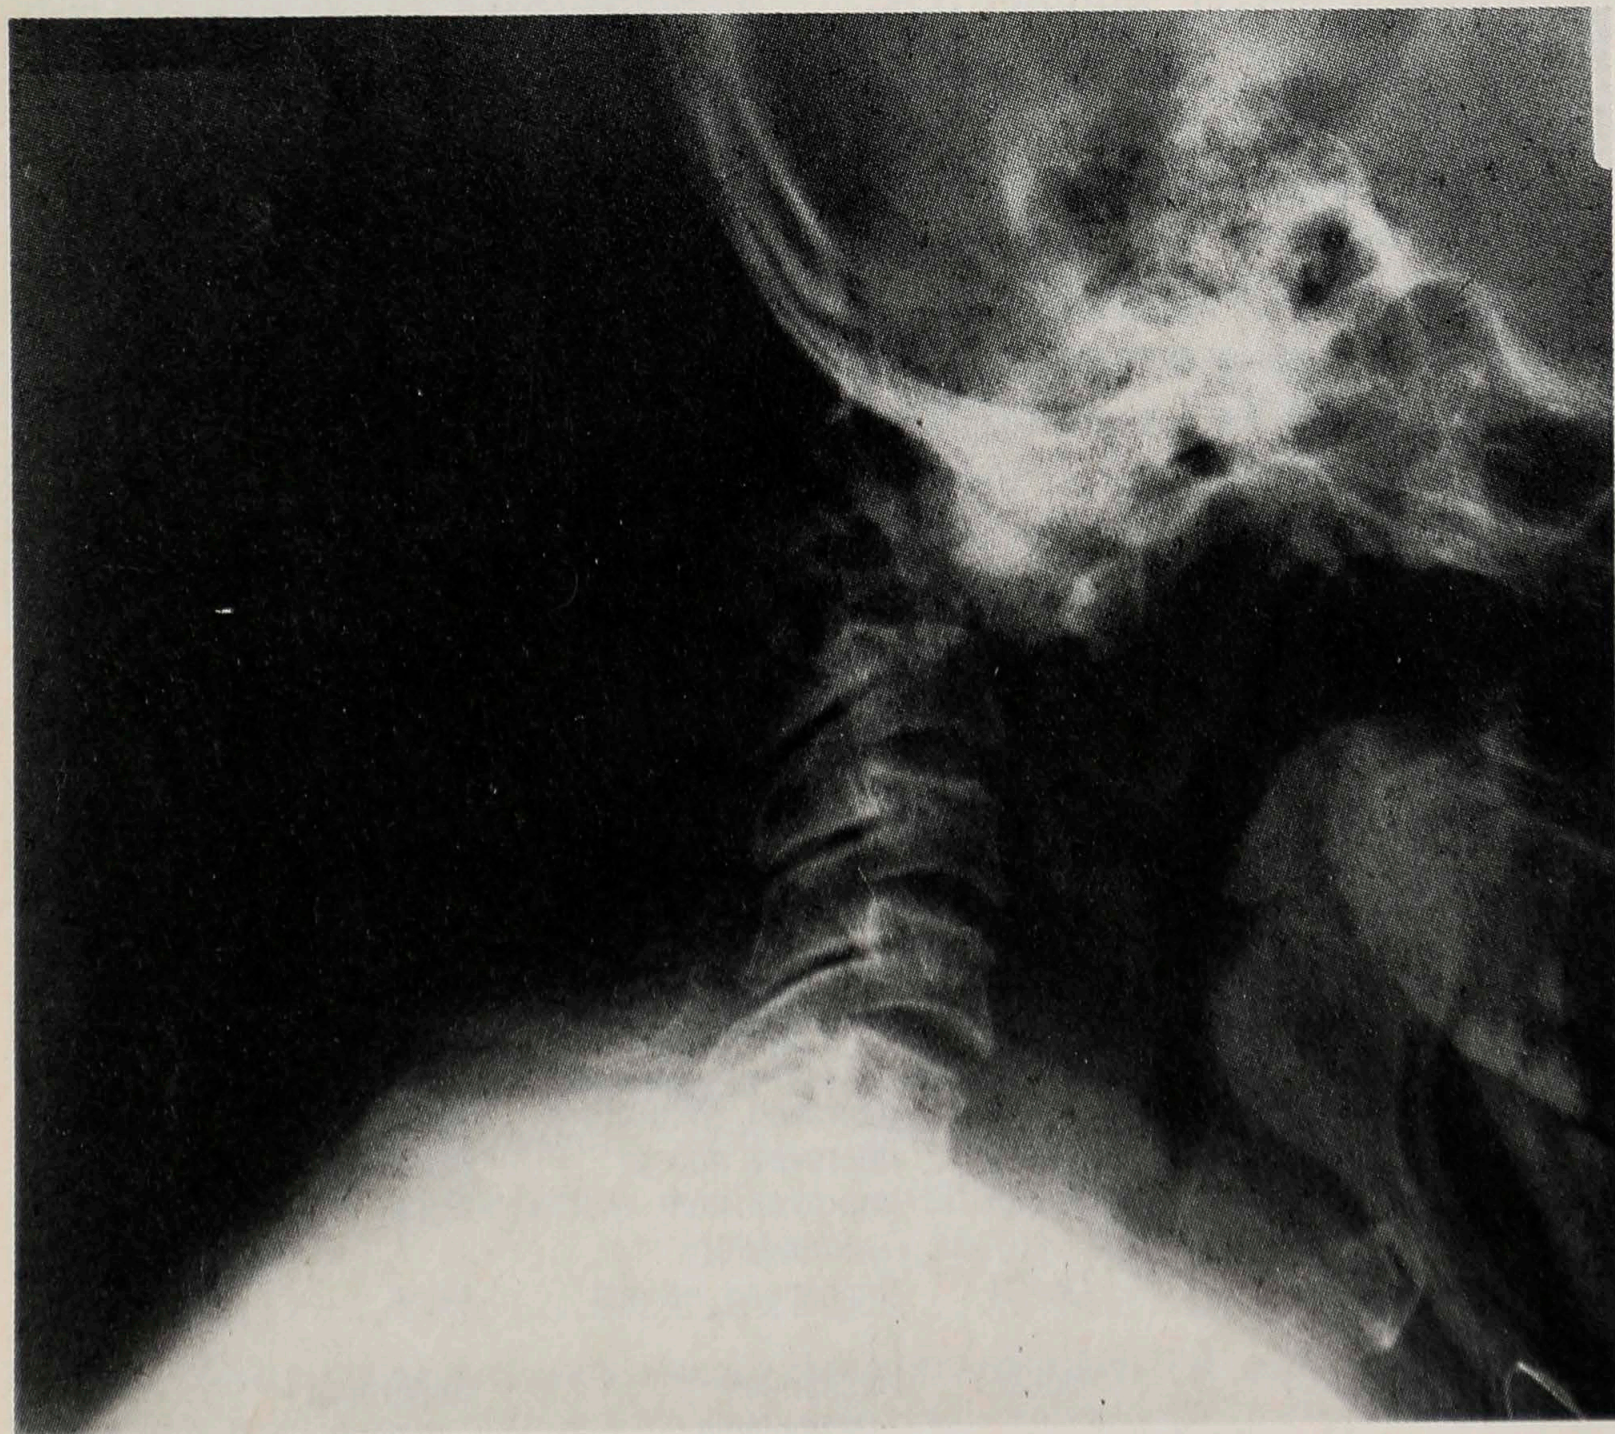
Lateral cervical x-ray film of 77-year-old man with pathologic fracture-subluxation of C2, secondary to prostate carcinoma metastasis (patient 4). After traction reduction, patient underwent occiput-to-C4 Luque rod fusion and remained neurologically intact.
